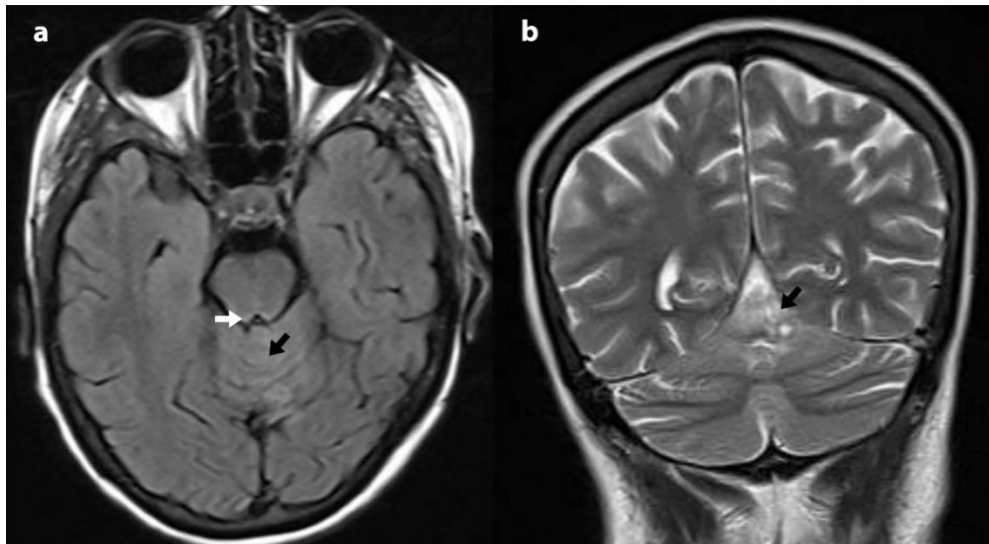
Axial brain magnetic resonance imaging (MRI) in FLAIR sequence (a) and coronal T2-weighted brain MRI showing ill-defined, hyperintense lesions at the bulbo-medullary junction without mass effect (white arrow in a). The presence of ill-defined hyperintense lesions in the cerebellar vermis (black arrows in a and b) were suggestive of cerebellitis.
